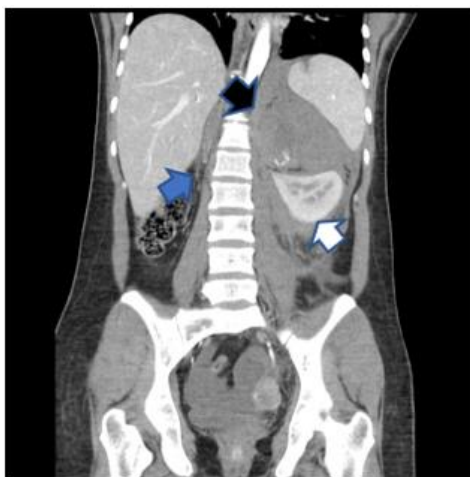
Axial Non-contrast Abdominopelvic CT, A large high attenuation collection and free fluid in the left retroperitoneum(white arrow), further more right renal agenesis and mesenteric lymph nodes
